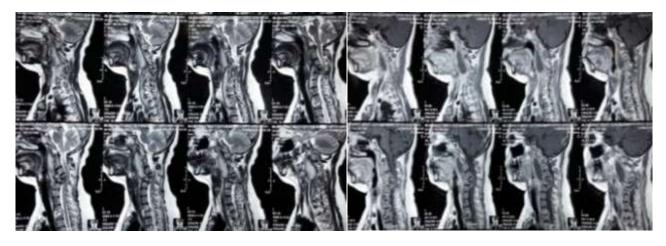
Sagittal Cervical MRI with sequences TI and T2
